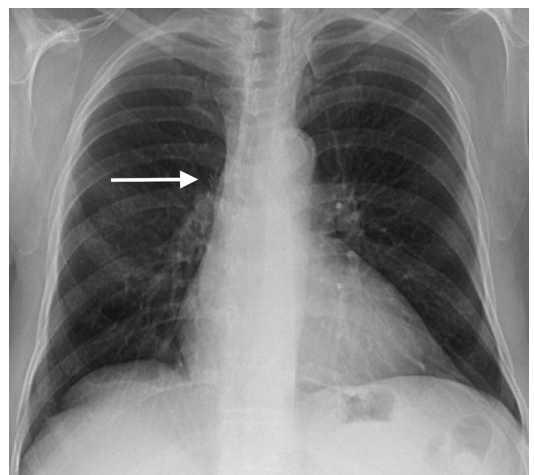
Posteroanterior chest radiograph demonstrating right upper lobectomy. There is right-sided volume loss, and surgical clips are seen at the right hilum (*arrow*). The hyperinflated right middle and lower lobes have shifted to occupy the vacant surgical space.
